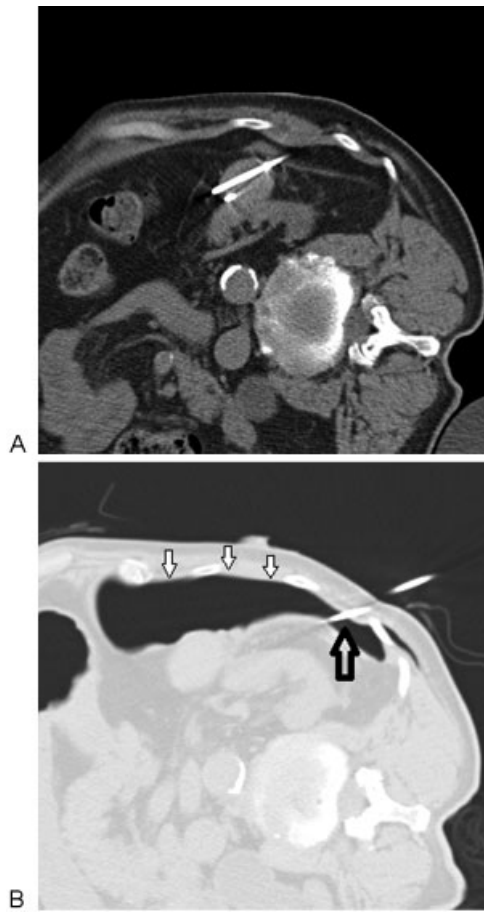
Pneumothorax during renal cryoablation. (A) CT image shows two cryoprobe within an exophytic left renal mass in an 82-year-old man. (B) CT image from a more superior level shows the cryoprobes crossing the pleural space (black arrow) with a moderate-sized pneumothorax (small white arrows). This was resolved with overnight catheter drainage. CT, computed tomography.
